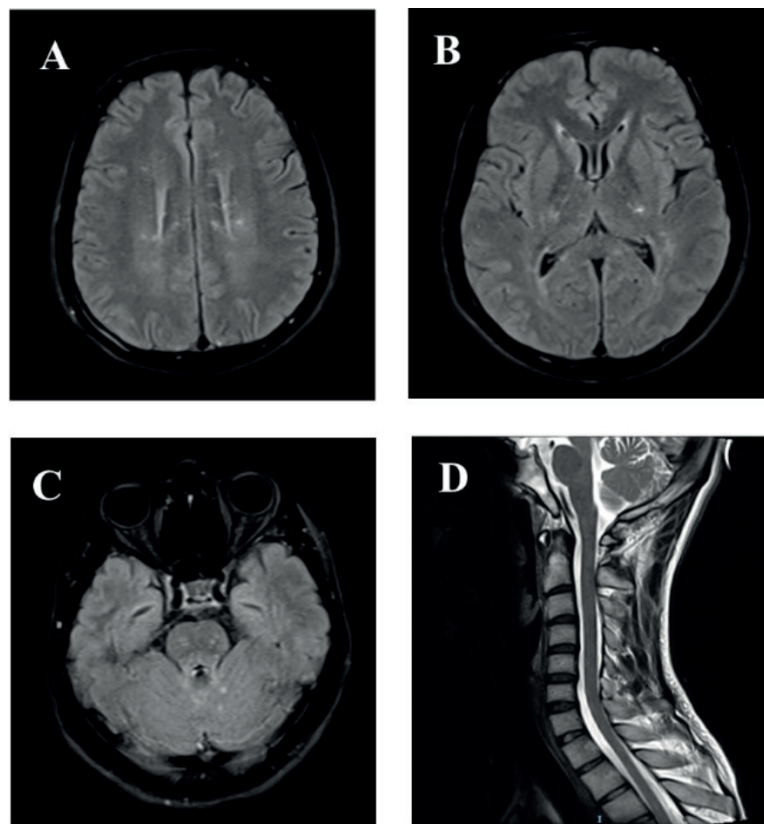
The patient's brain and cervical T2 MRI sequence. Hyperintense signals in the lateral ventricle, brainstem and cerebellum (A-C) and slight protrusion of cervical 3-4, 4-5, 5-6 intervertebral discs (D).
